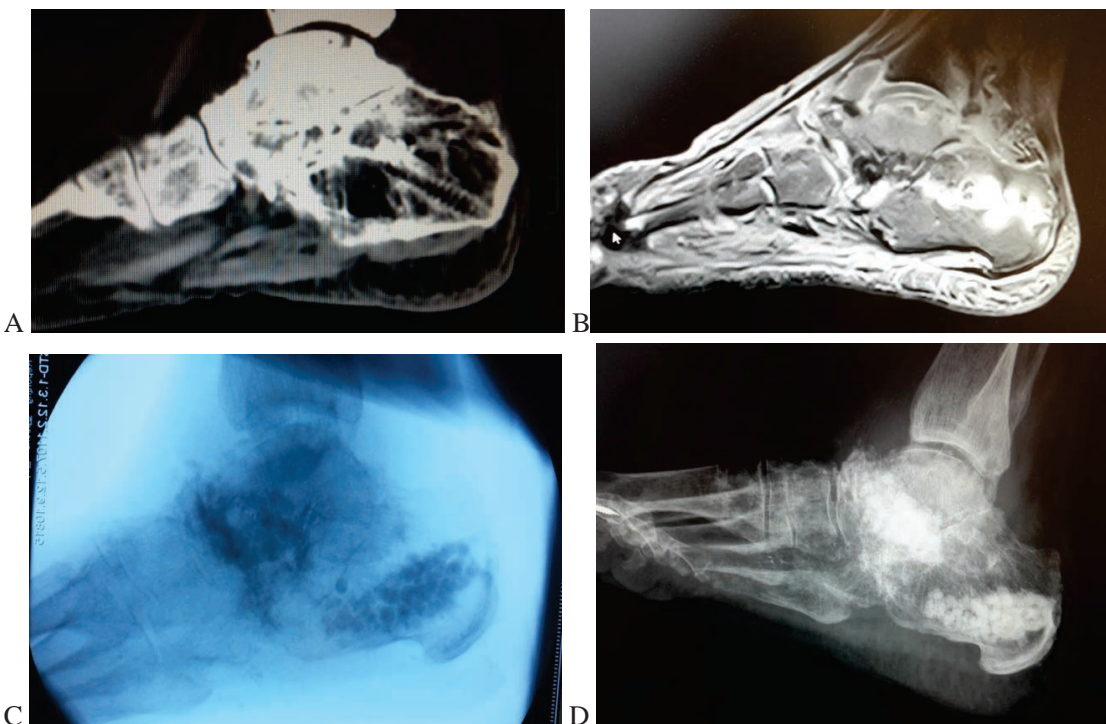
Filling of cavitory bone defect with Stimulan bone substitute in pellets after debridement of infectious focus in calcaneus; preoperative CT (A) and MR (B); intraoperative control of placement of pellets with fluoroscopy (C); postoperative radiograph (D).
